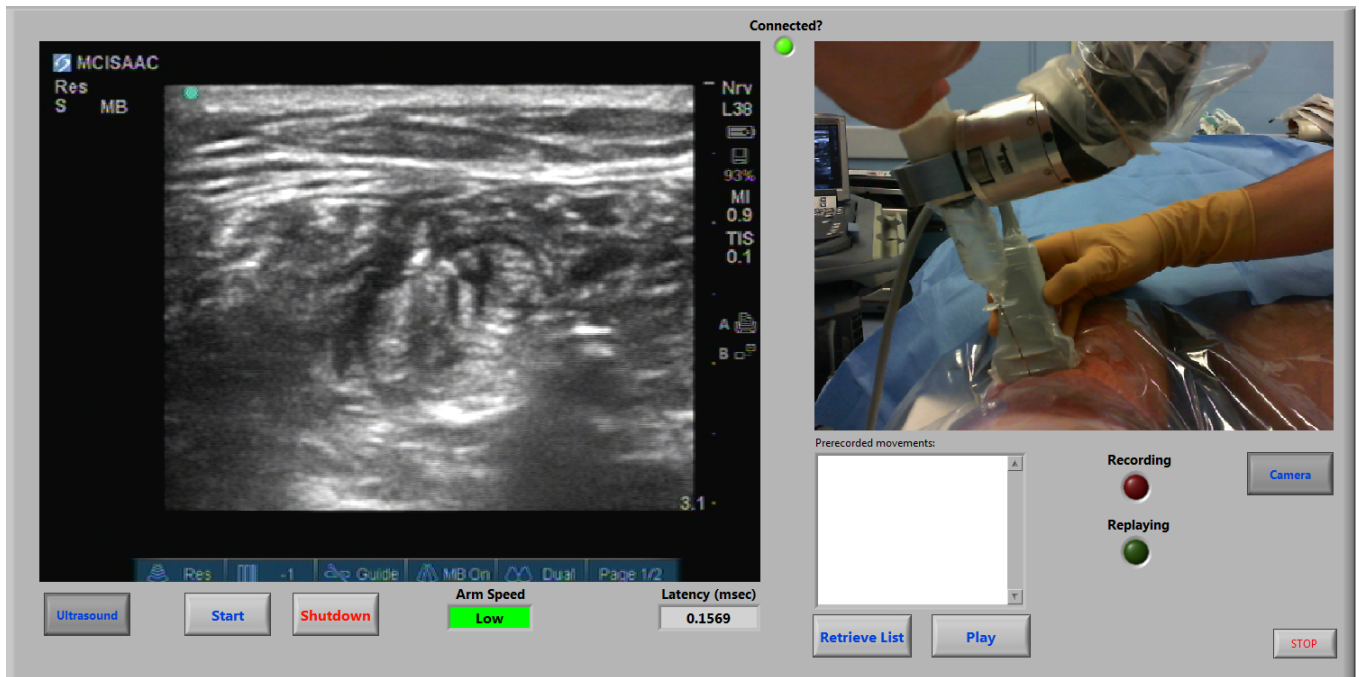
GUI of the Magellan system. Left: Ultrasound video feed. Right: Webcam video showing ultrasound probe and insertion area. The arm speed and network latency are displayed beneath the ultrasound video.
